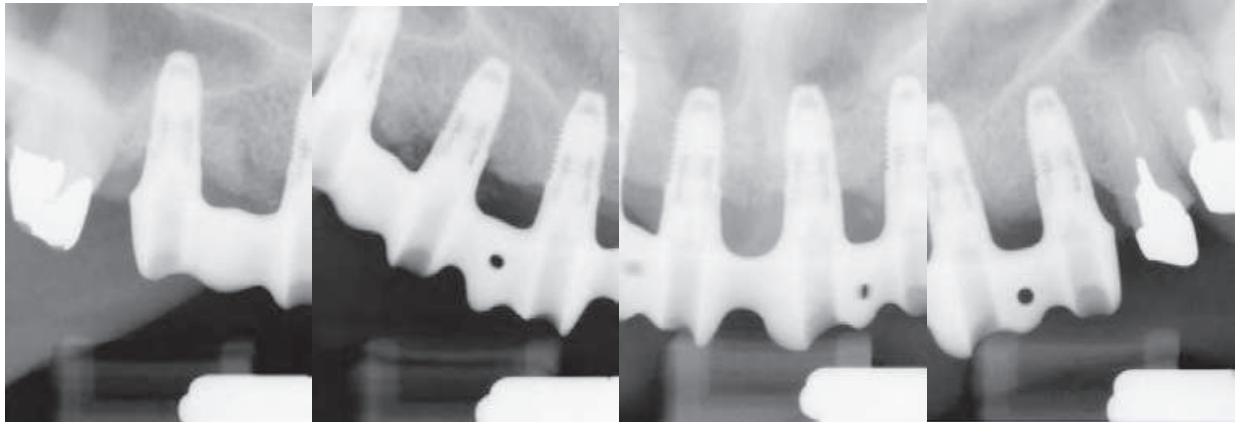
Radiographic verification of framework fit prior to placement of superstructure.
